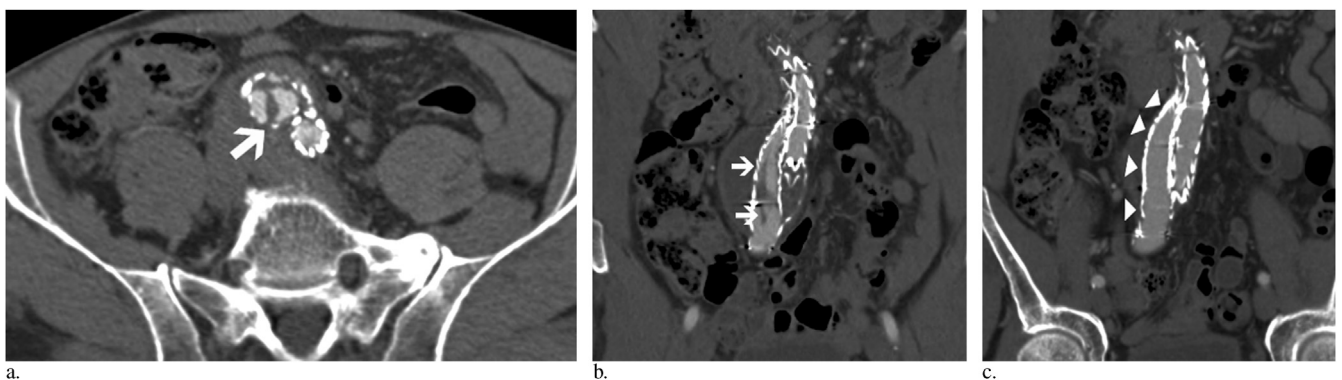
(a) Axial CT scan performed 6 months after EVAR reveals a floating thrombus (arrow) in the right stent graft limb. (b) Corresponding coronal CT reconstruction shows the floating thrombus (arrows) in the distal part of the right stent graft limb. (c) Axial CT scan performed 2 years after relining with an e-PTFE-covered Excluder stent graft limb shows absence of any thrombotic material in the right relined stent graft limb (arrowheads).
